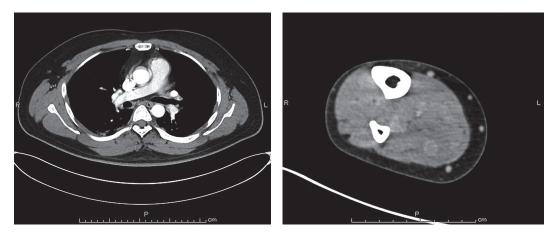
Contrast-enhanced computed tomography on day 16. It revealed pulmonary embolism and deep vein thrombosis in the right lower limb with perivascular inflammation.
